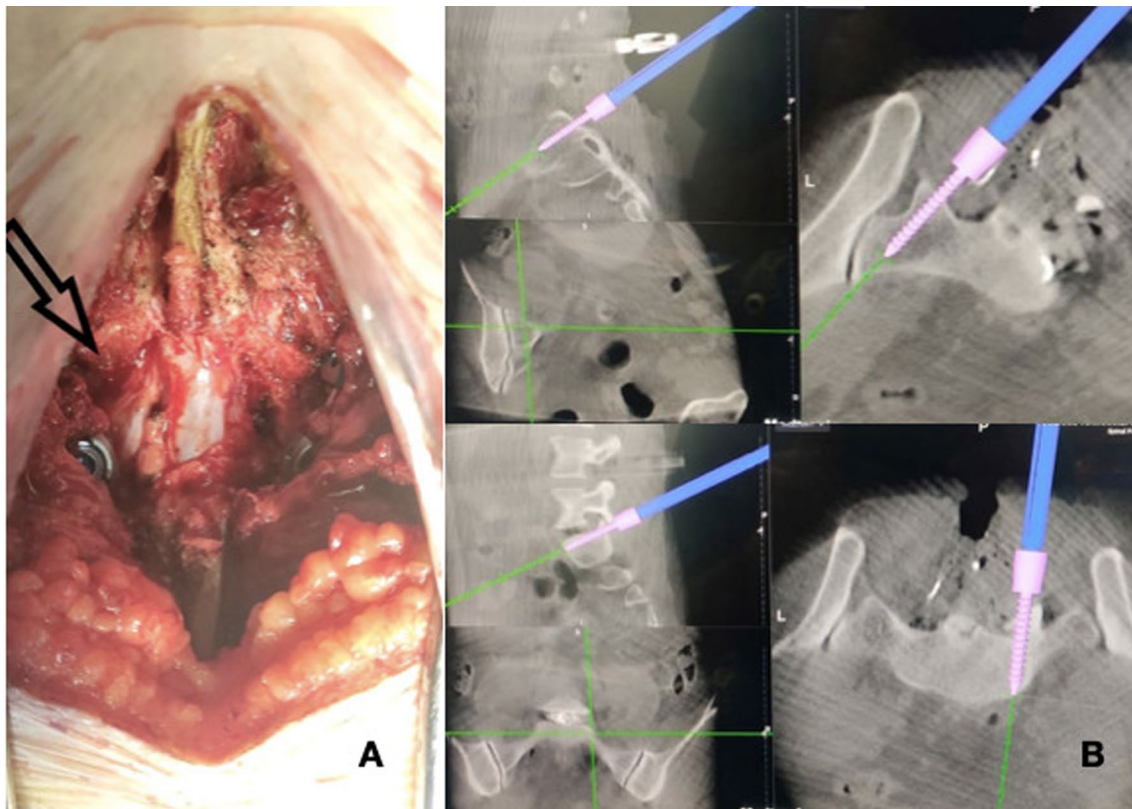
a During intra-operative exploration in case 2 a conjoint nerve root at left L5 level (type 2b- Neidre and MacNab) with absent S1 pedicle on left was found. b Intra-operative O-arm and CT navigation picture showing placement of screws. The Left S1 screw was placed using a lower entry point and divergent direction towards the sacral ala
